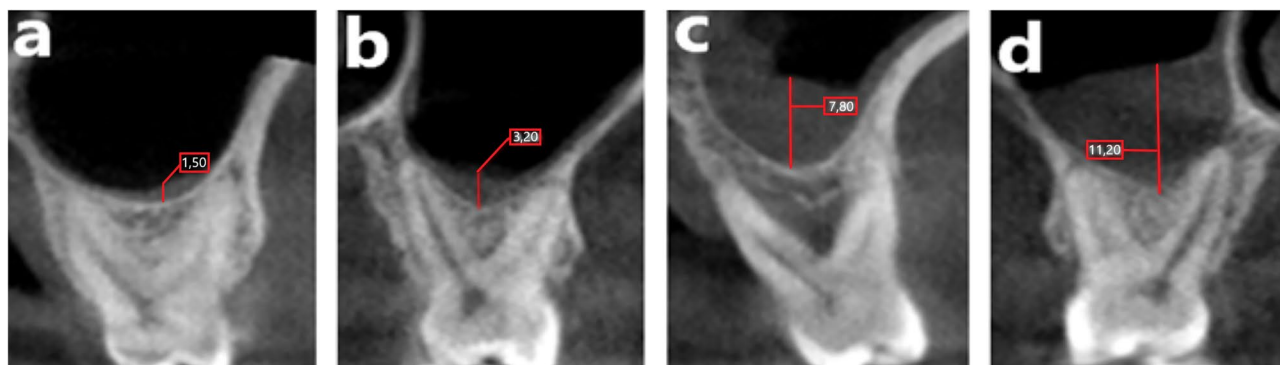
CBCT images showing the sinus mucosal thickness value. a Class I (<2 mm) b Class II (2.1–5 mm) c Class III (5.1–10 mm) d Class IV (>10 mm). Note: The red line indicates the site of sinus mucosal thickness measurement
